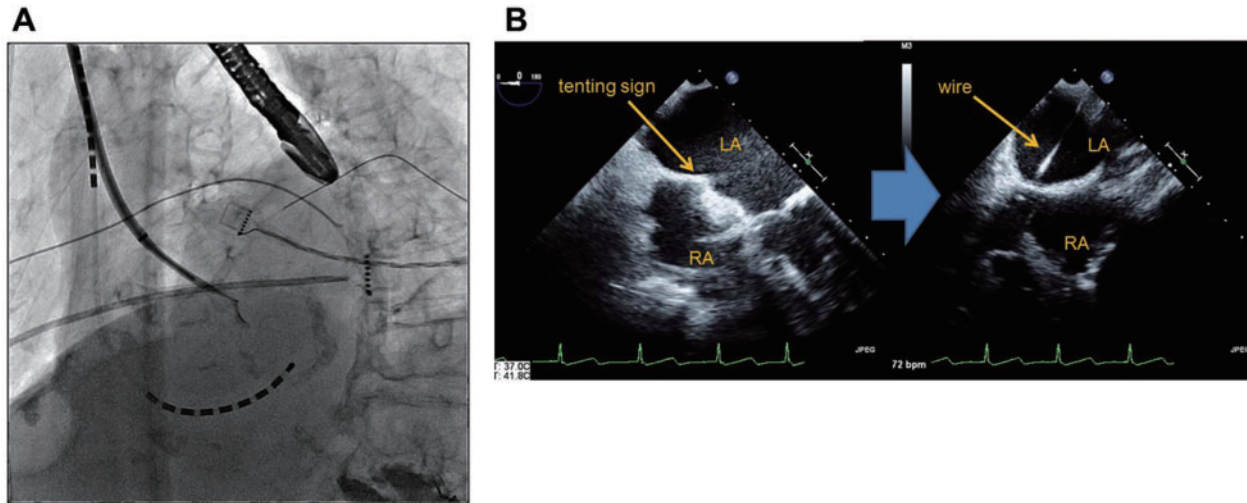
(A) Radiography of the transseptal puncture. (B) Transoesophageal echocardiography of the transseptal puncture. LA, left atrium; RA, right atrium.
